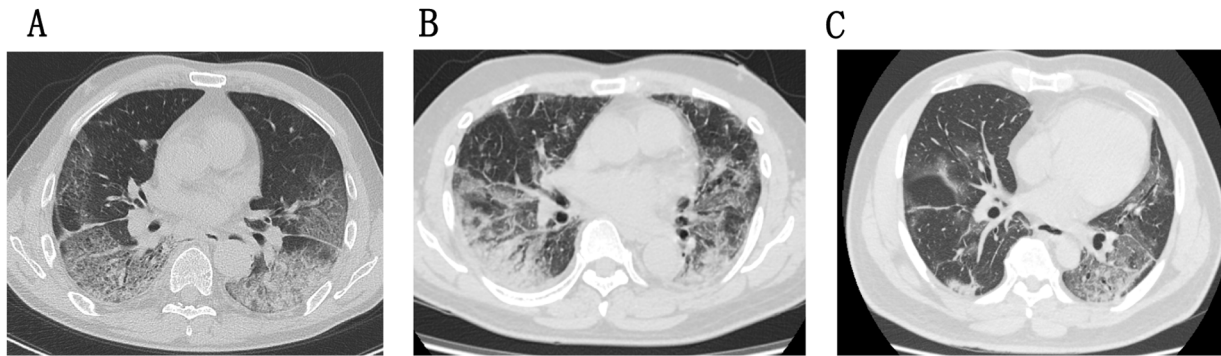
Chest computed tomography (CT) scans for three patients.
